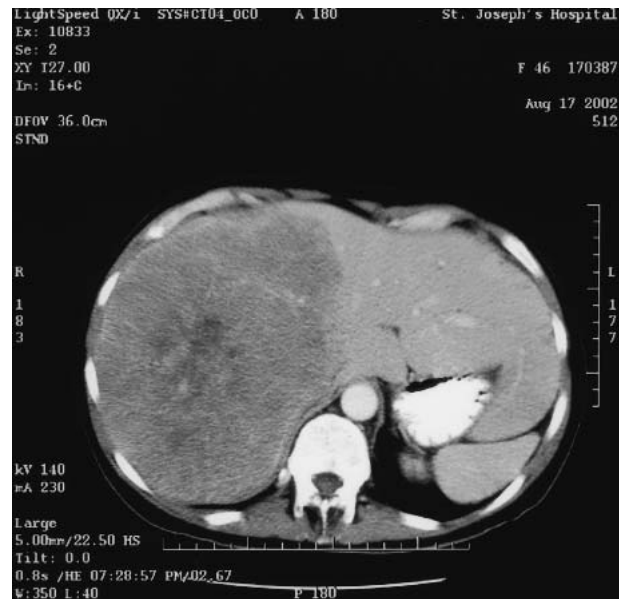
CT scan of Patient 2 demonstrating extensive colon metastasis in the liver.
